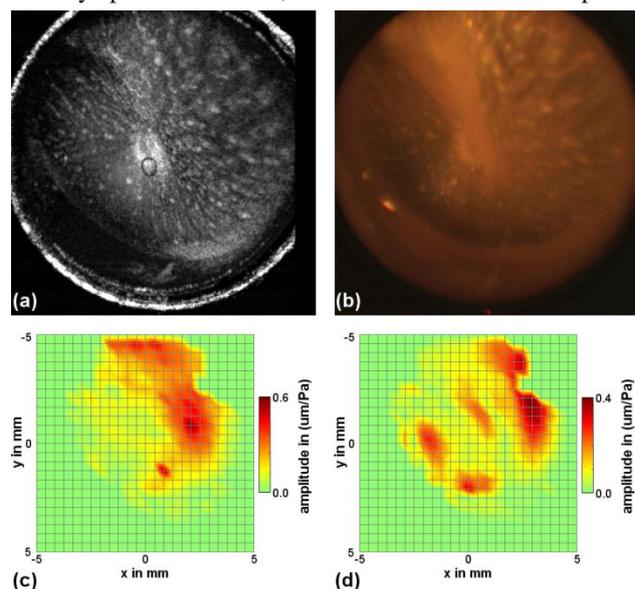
Imaging results showing (a) the depth projection of the OCT volume scan, (b) the corresponding video endoscope image and (c, d) the oscillation amplitude maps for 1092 Hz (c) and 3034 Hz (d), which have been calculated from the functional Doppler-OCT scan.
